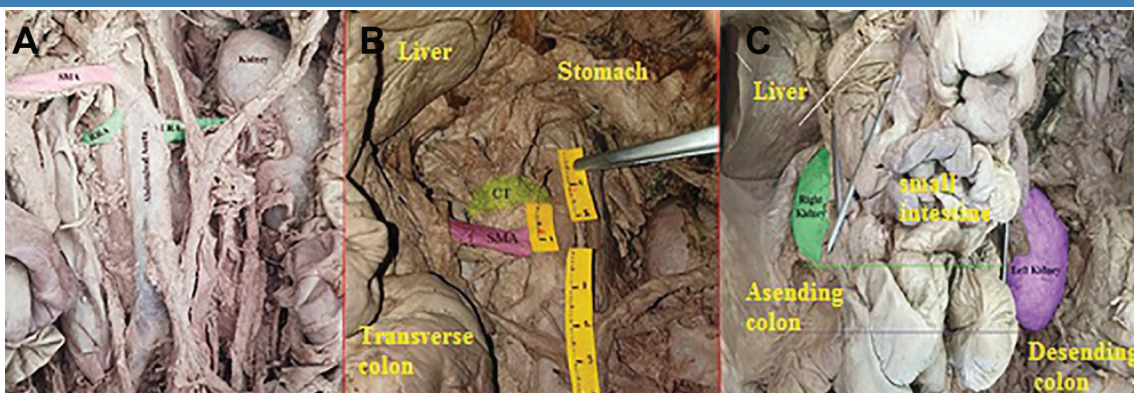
Positional variation of kidneys and their arteries is shown. (A) Renal arteries, slightly lower than the origin of the superior mesenteric artery (SMA), were branched from the abdominal aorta but the right renal artery (RRA) were originated from the abdominal aorta to a higher position than the left renal artery (LRA). (B) The distance between the celiac trunk (CT) and aortic hiatus was 1.2 cm, between the CT and SMA was 0.7 cm, between SMA and IMA was 5.2 cm, and between IMA and aortic bifurcation was 3.7 cm. (C) Inferior pole of the left kidney is higher than the inferior pole of the right kidney.
